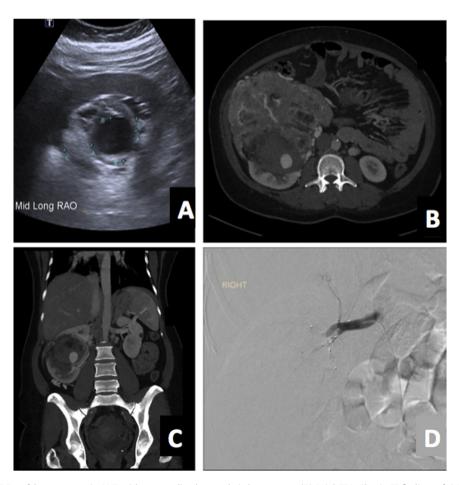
(A) Ultrasound: 3.8 × 3.3cm false aneurysm in AML with surrounding hyperechoic haematoma. (B) Axial CTA: Classic CT findings of right AML, a heterogenous mass with apredominence of fat (-20 HU) and intersperesed tissue density (muscular andvascular elements). 4.5% of AMLs are a 'minimal fat' subtype which impedes the reliability of CT diagnosis [7]. Large false aneurysm arrowed. (C) Coronal CTA: Haemorrhage and largefalse aneurysm within right AML, incidental left AML. (D) Digital Subtraction Angiogram: Embolised proximal right renal artery.
